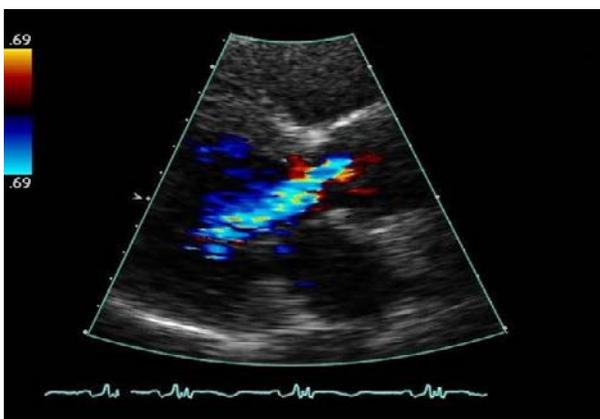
Transthoracic echocardiogram showing Aortic regurgitation.
